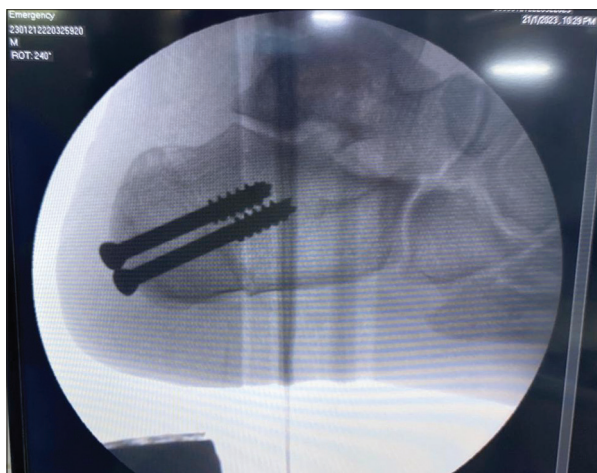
Radiograph showing post-operative lateral view of the right foot.
